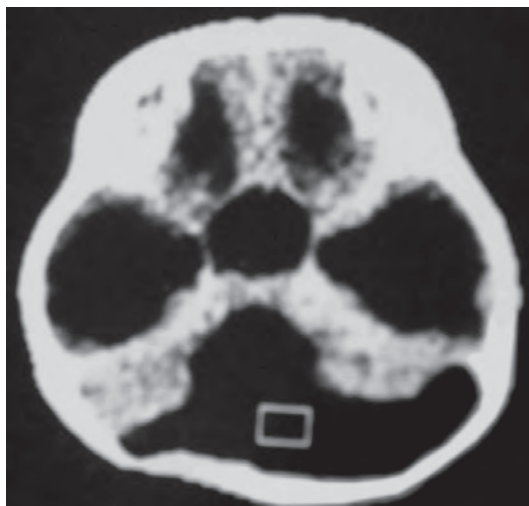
CT scan of the brain showing Dandy Walker malformation variant
